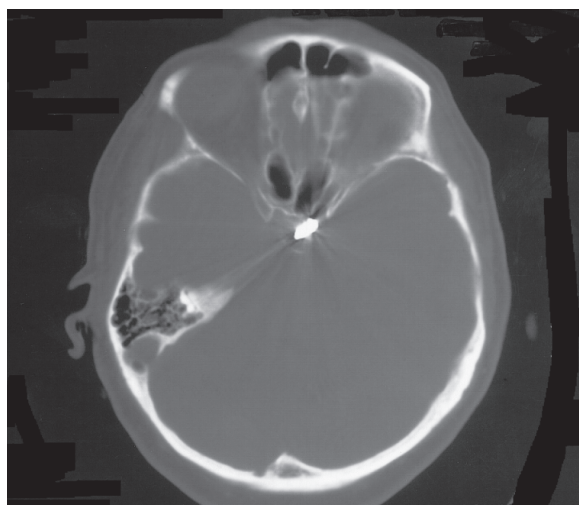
Axial CT bone window image through the top of the sella turcica shows coil mass.
